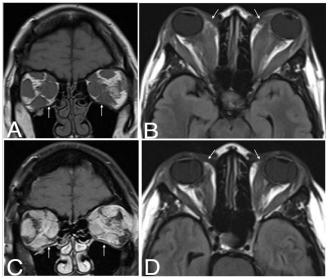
Diffuse enlargement of extraocular muscles on magnetic resonance imaging. Enlargement of extraocular muscles, proptosis and soft tissue enlargement (arrows) is seen on coronal T1 pre-contrast (A) and axial T2 FLAIR (B) images. Diffuse enhancement involving retroorbital fat (arrows) is seen on coronal post contrast T1 image (C). Follow-up MRI (D) one month later shows marked improvement in proptosis and extraocular muscle infiltration (arrows).
